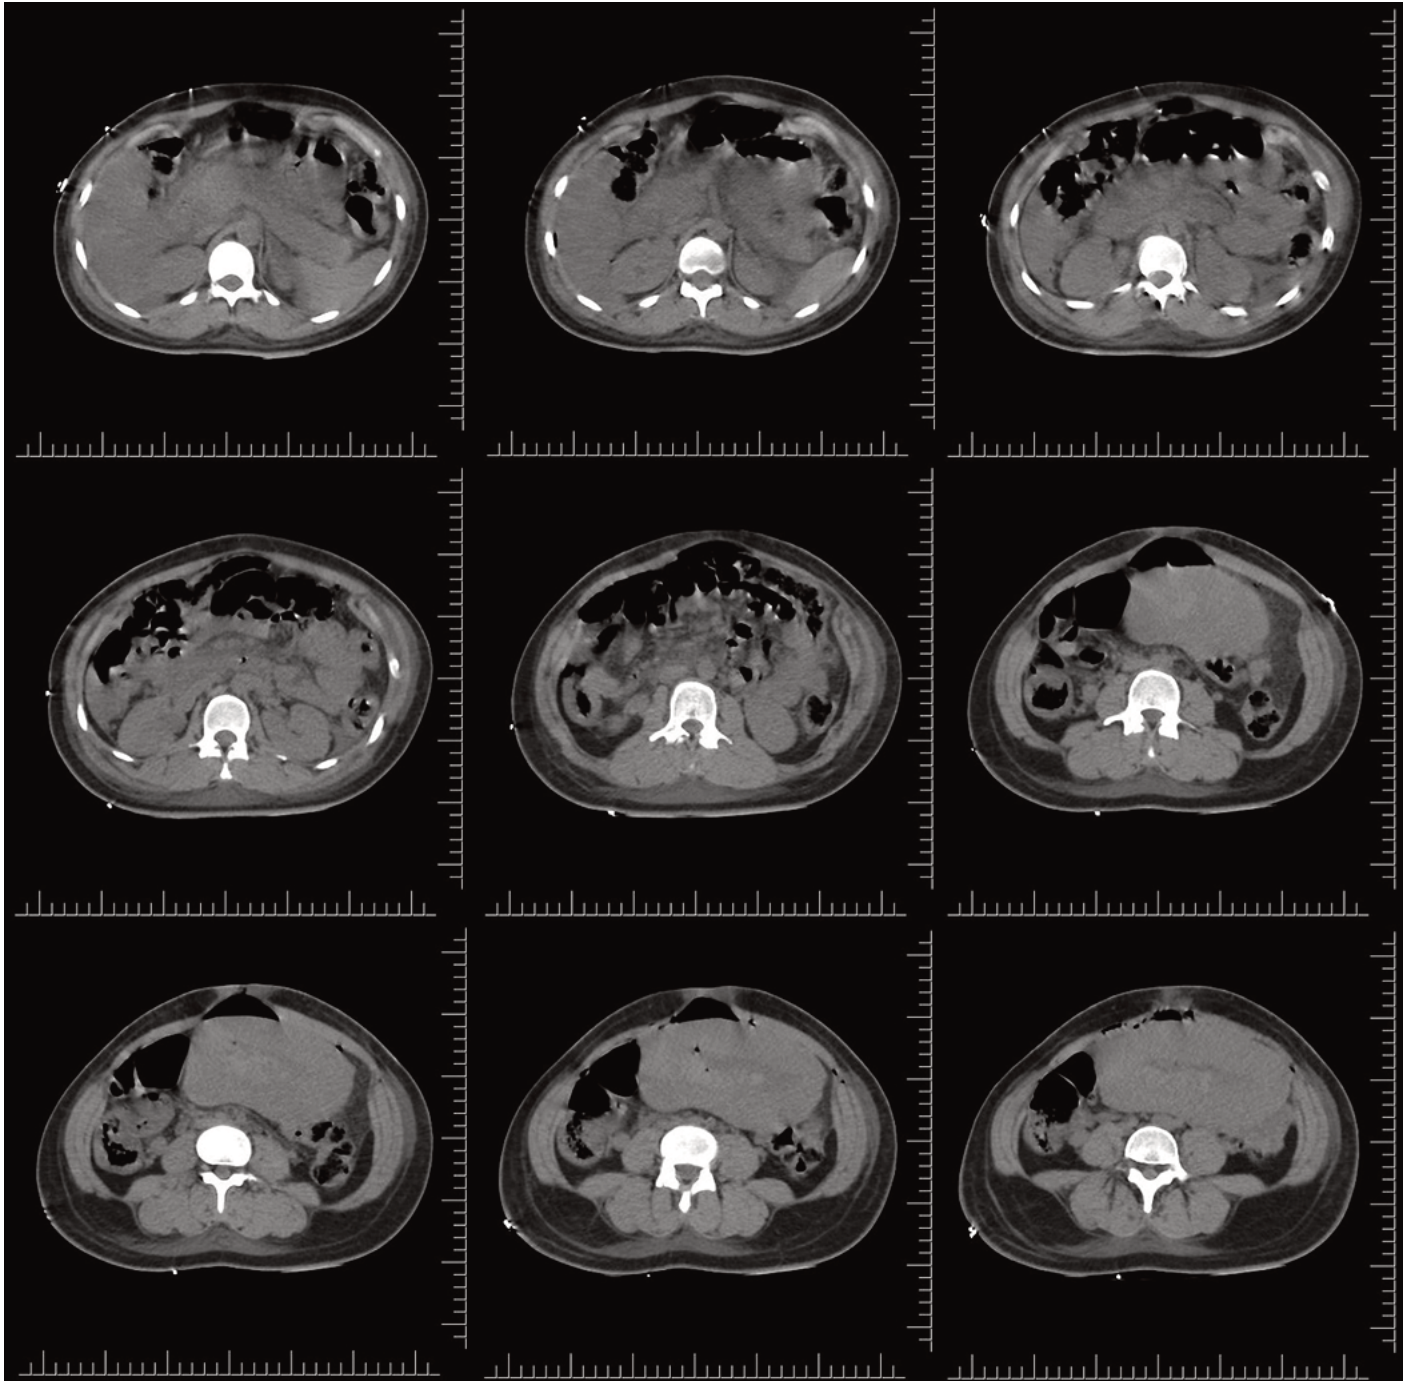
Transversal slices of simple computed tomography of the abdomen showing pneumobilia, prominence of the body and tail of the pancreas, post-surgical pneumoperitoneum, free fluid in the perisplenic space, in the splenorenal recess, and in both paracolic gutters; a uterus in a puerperal state with the presence of hyperdensities likely containing blood; and soft tissue edema and emphysema in the hypogastrium.
